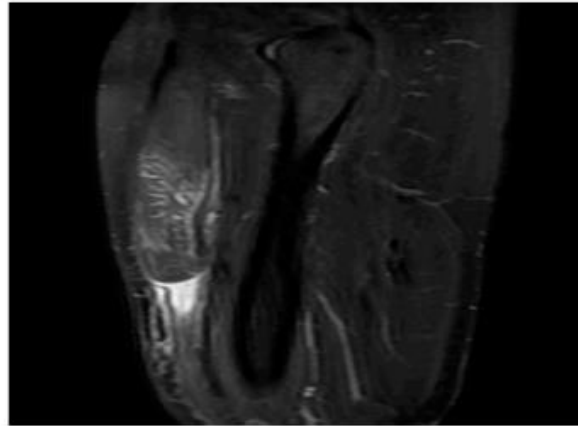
Coronal T2-weighted MRI sequences without (a) and with fat saturation (b) demonstrating proximal ascent and retraction of the rectus femoris muscle belly. The distal tendon is absent, replaced by a fluid collection in T2 hypersignal
